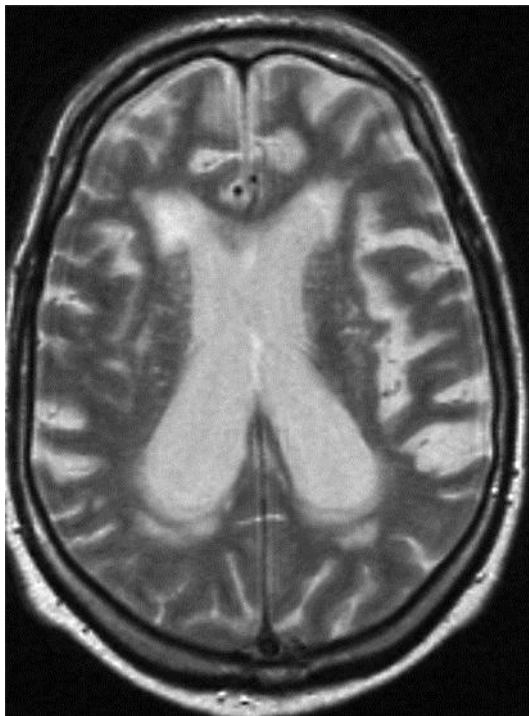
Non-contrast MRI of the patient's brain shows slight atrophy, ventricular enlargement and cerebral microangiopathy.
